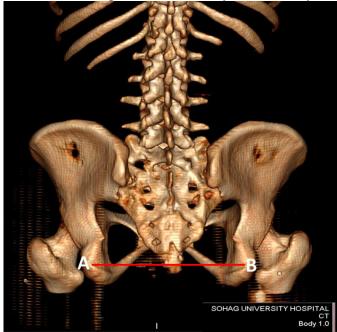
An Image of pelvic 3D volume rendered reconstruction of CT scan; Bituberous . Diameter extending between both ischial tuberosities (A) and (B)
